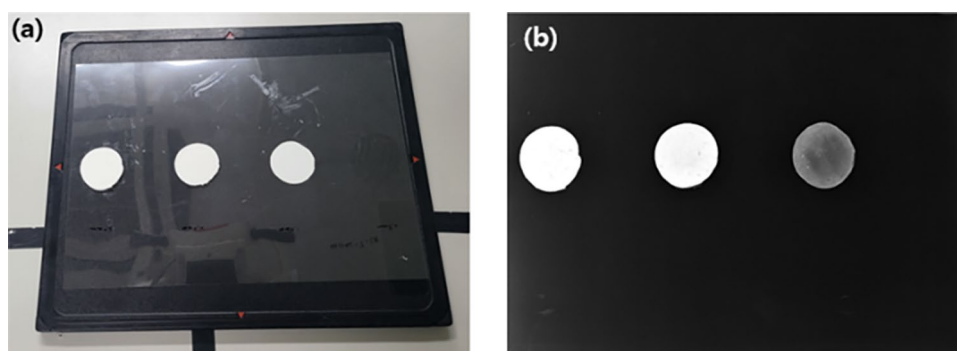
X-ray imaging (80 keV, 20 mA) of dispersed barium sulfate.
